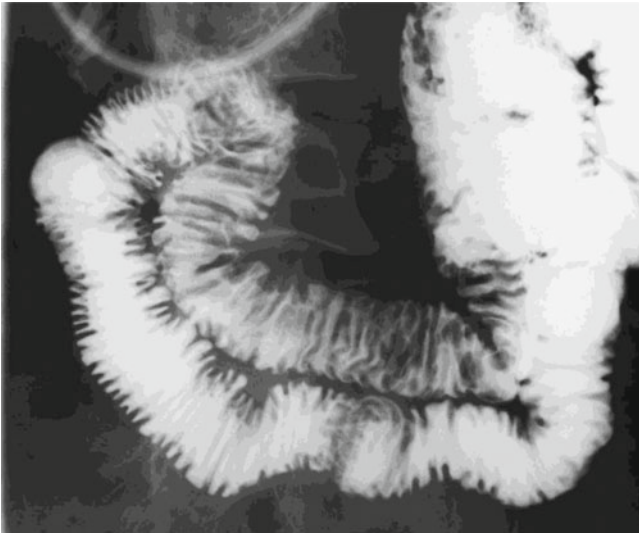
Radiography showed swollen Kerckring's folds due to edema in the ileum
